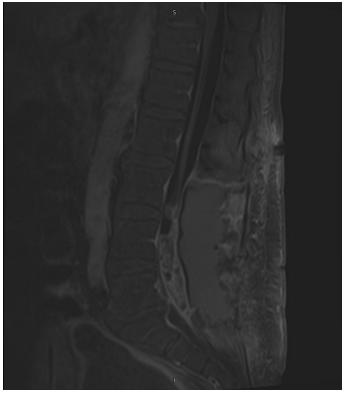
51-year-old male with progressive weakness of bilateral lower extremities. MRI Lumbar spine, 1.5 tesla T1 post-contrast, post treatment Demonstrates heterogeneous enhancing mass and multiple small cystic changes noted and appearance of split of the cauda equina.
